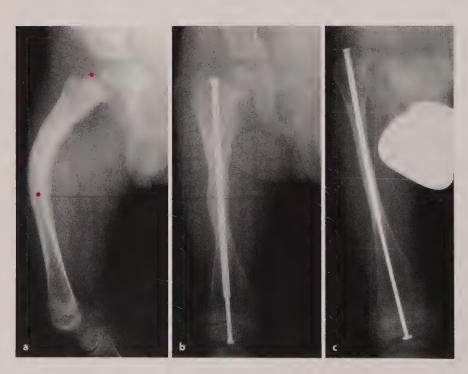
Femoral telescopic rodding with Bailey-Dubow rods. a Preoperative radiograph; b 3 months and c 4 years postoperatively
